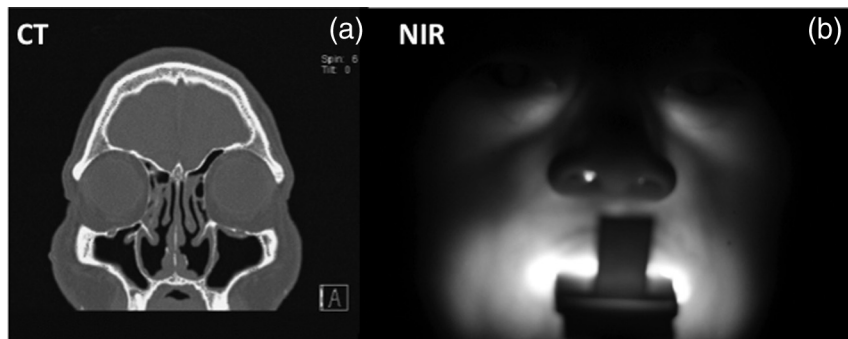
Patient #3 with representative CT slice (a) and NIR image (b). Note that the patient's right sinus cavity is slightly smaller in volume due to the thickening of the membranes observed near the bottom of the right maxillary sinus cavity.
